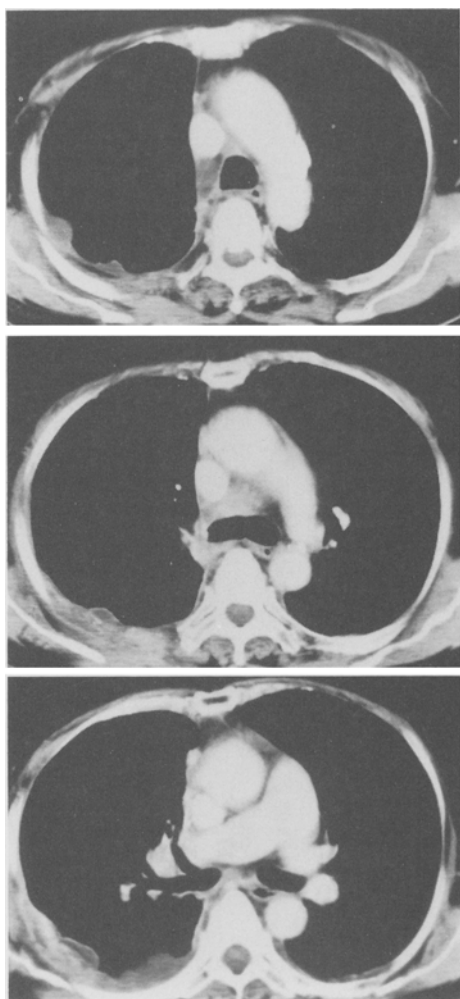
Computed tomograms of the chest at the level of carina showing slight pleural effusion and no dissecting or aneurysmal change on the thoracic aorta except for calcification.
